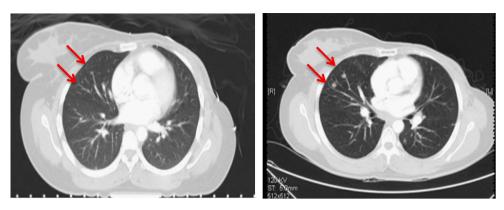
(a) Indeterminate nodules in the right lung on planning computed tomography (CT) scan. (b) Subsequent CT scan of the thorax showing progression of the same nodules to lung metastases.
